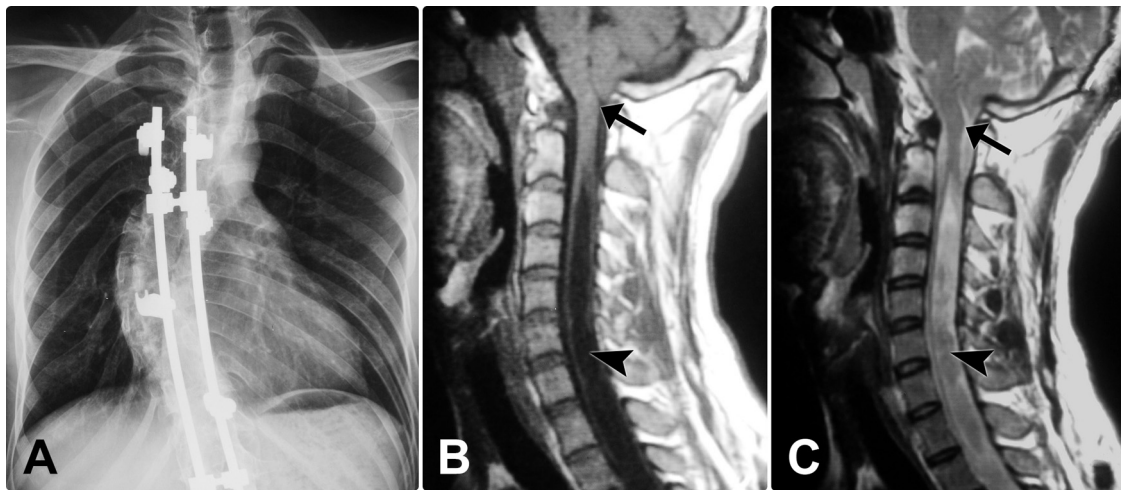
X-ray of the patient 1 shows scoliosis (A). Preoperative sagittal T1-weighted (B) and T2-weighted (C) MR images demonstrate CM 1.5 with syrinx (arrowheads). The obex was below the foramen magnum (arrows).
